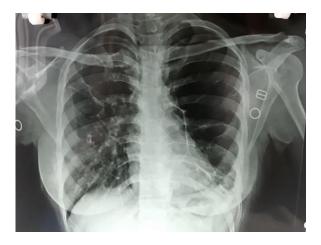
Repeat chest X-ray taken after 9 months showing stable disease.
